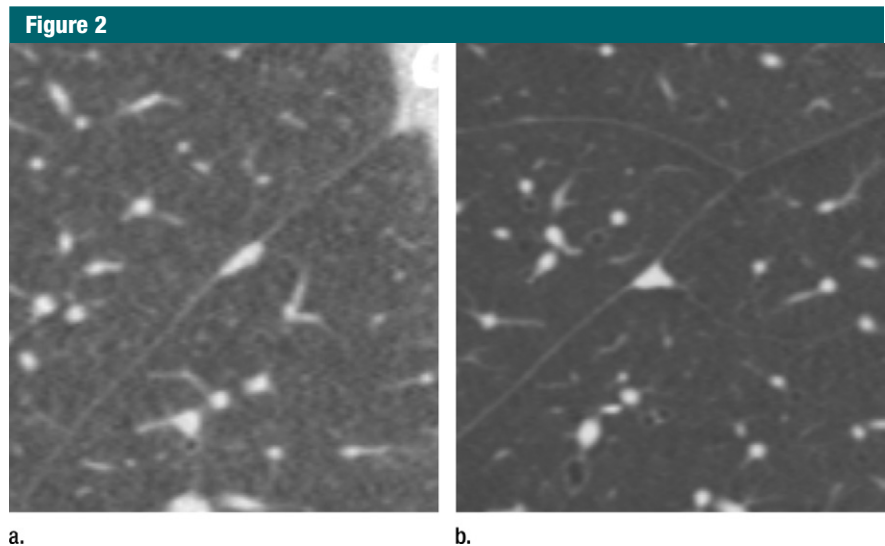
Sagittal CT images show examples of typical PFNs with (a) lentiform or (b) triangular shape.
